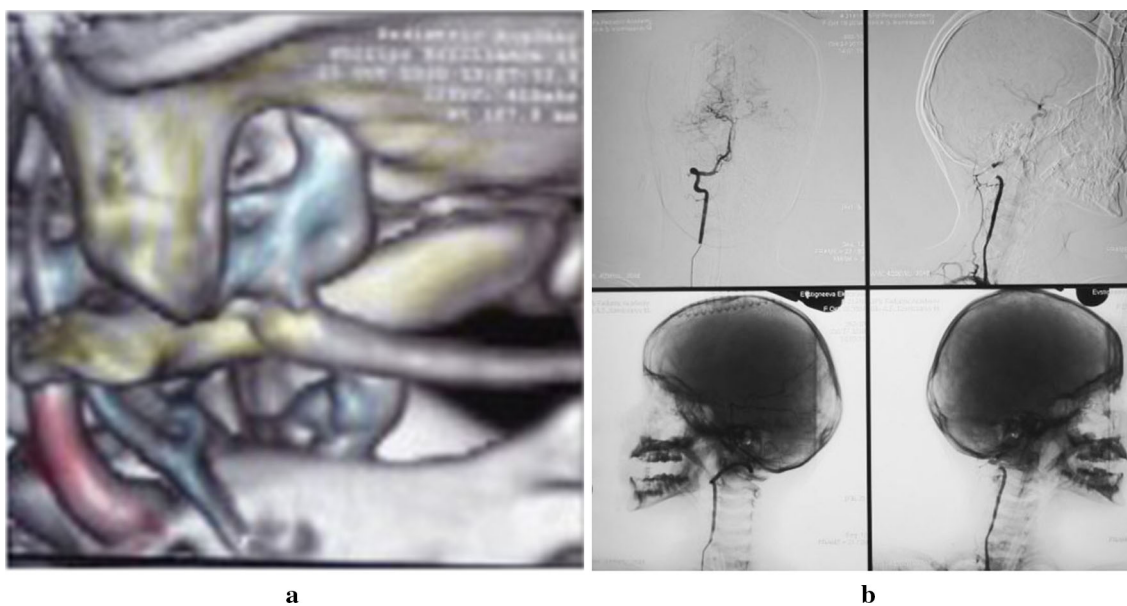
Angio-CT scan (a) and X-ray angiogram (b) with a functional head-turning test in the 6-year-old girl (case no. 2). Compression of the right vertebral artery while turning the head to the left
